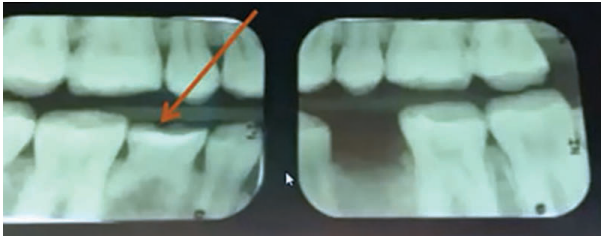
Bitewing radiographs showing the presence of retained tooth 85, and the absence of clinical findings explaining the patient's concerns.
